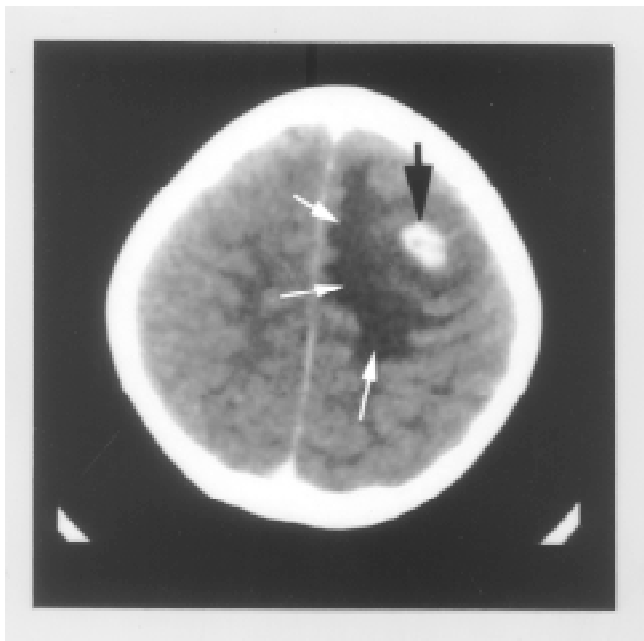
Contrast enhanced (CE) CT head showing intracranial tuberculoma (black arrows) and perilesional oedema (white arrows).
